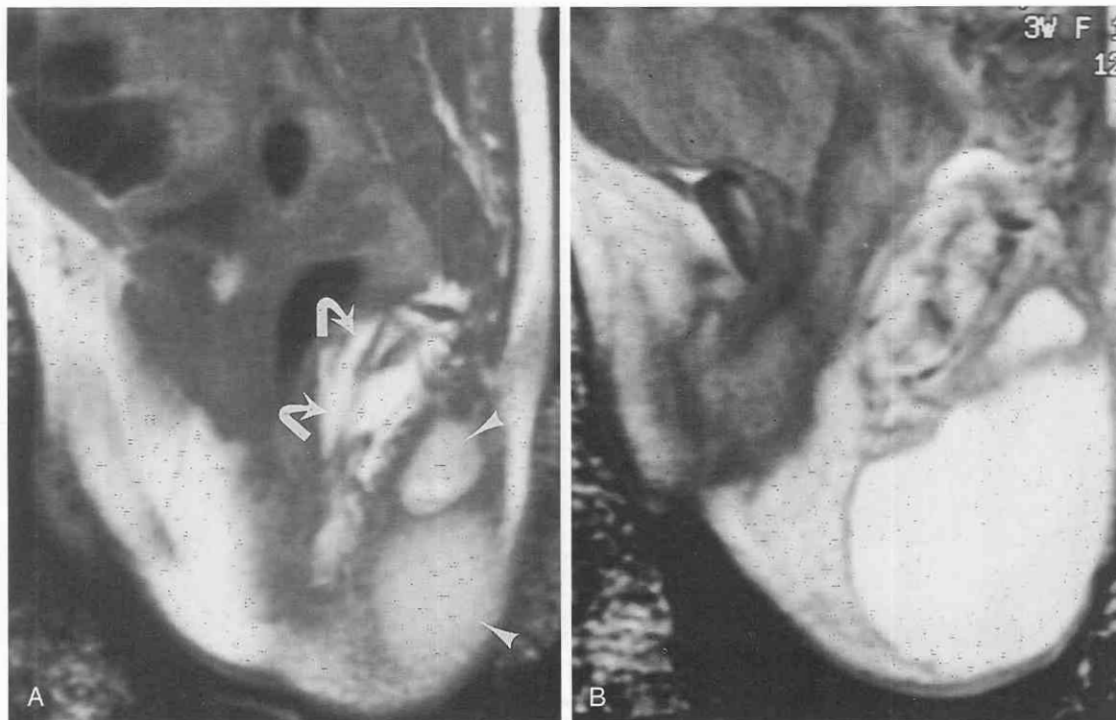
Benign sacrococcygeal teratoma. *A*, T1-weighted (500/16) image shows a large pelvic mass with external and presacral components. The presacral components (*curved arrows*) have a high signal intensity similar to that of subcutaneous fat. The larger posterior portion of the mass (*arrowheads*) extending into the gluteal muscles has an intermediate signal intensity. *B*, On a T2-weighted (2500/90) image, the presacral mass again has an intensity equal to that of subcutaneous fat. The extrapelvic portion of the tumor has a signal intensity higher than that of fat, consistent with fluid. A predominantly cystic mass with fat and few soft tissue elements is characteristic of a benign teratoma. (Courtesy of Andrew Landes, M.D., Hollywood, Fla.)
